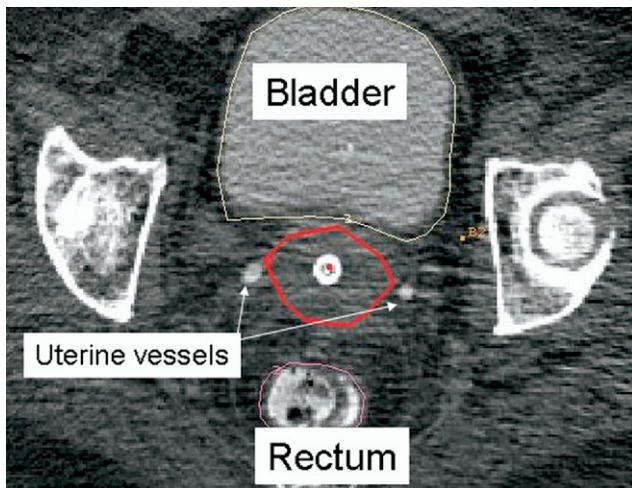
Axial computed tomography image at level of cervix/uterine interface in Fédération Internationale de Gynécologie et d'Obstétrique Stage IB cervical cancer. Intravenous contrast delineates uterine vessels and may assist with identifying superior border of cervix. Bladder and rectal contrast inserted at computed tomography scanning aid in delineation of these structures.
